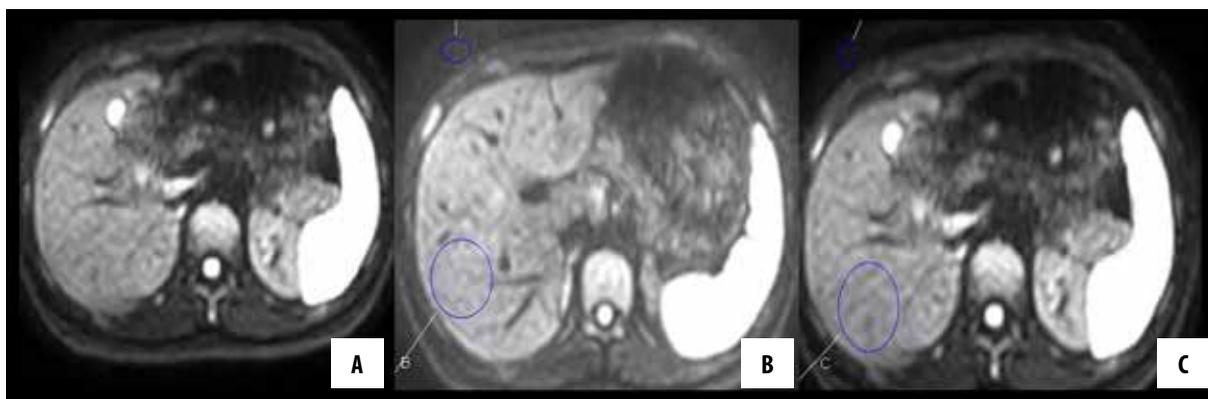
Transverse diffusion-weighted single-shot echo-planar raw image with parallel imaging and fat saturation in a 25-year-old woman (A) and signal-to-noise ratio measurements for the liver in breath-hold (B) and free breathing (C) DWIs at b value of 600 s/mm^2 . SNR measurements for the liver in BH DWI was 26 and FB was 53.3 for this case.
